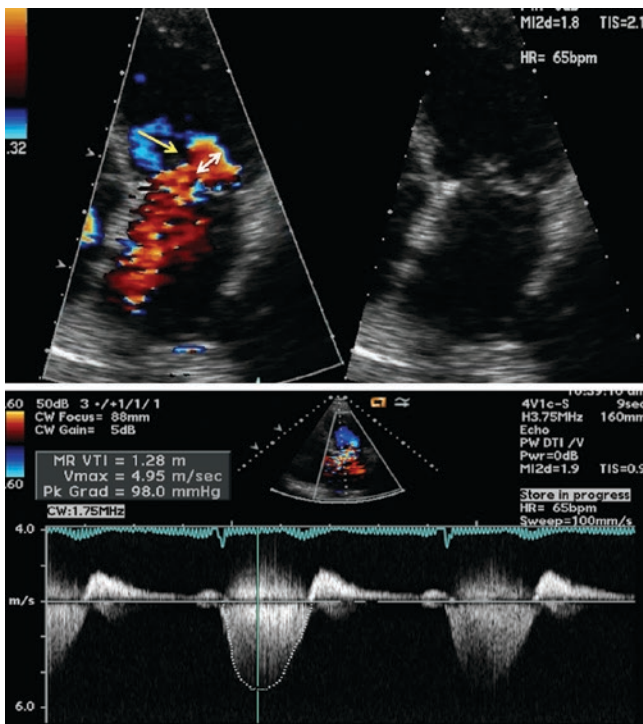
Quantification of mitral regurgitation requires identification of the zone of flow convergence. One should identify the narrowest portion of the jet as demonstrated by the yellow arrow (vena contracta). Also, one should identify the PISA radius (white arrow) to allow for calculation of the effective regurgitant orifice area (EROA) using the PISA method. The echocardiographer should also obtain a continuous wave Doppler of the mitral regurgitation since the peak velocity and the velocity time integral are also used to calculate the EROA and the regurgitant volume
